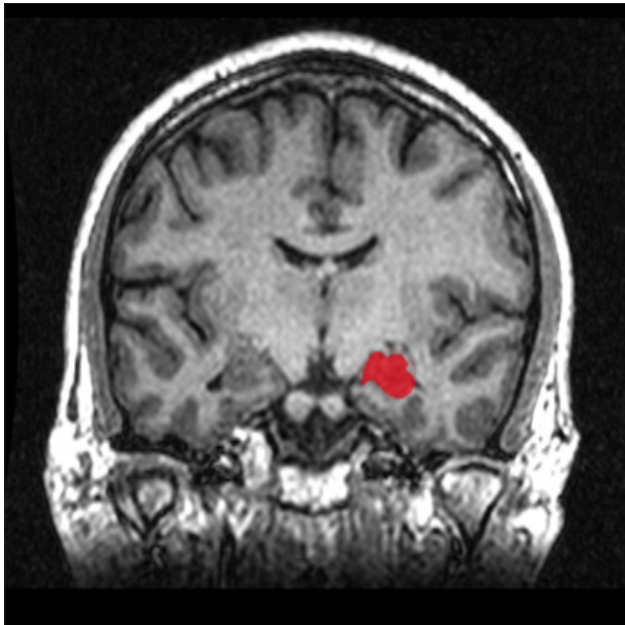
MRI in coronal plane showing a normal hippocampal volume in red.
